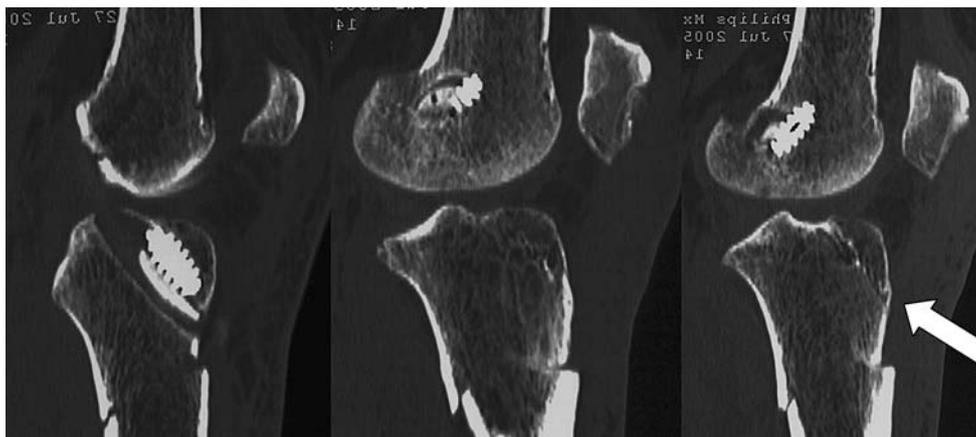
Sequential CT scans showing sagittal images of tibial bone tunnel, uninvolved tibia, and proximal extension of fracture through the donor site (*arrow*)
